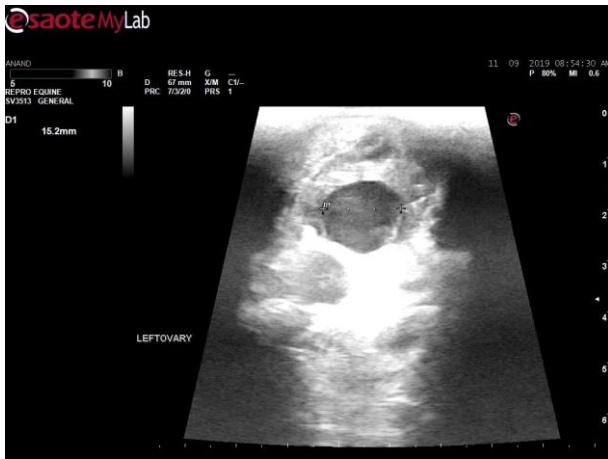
Ultrasound image of the left ovary showing 2 large follicles
